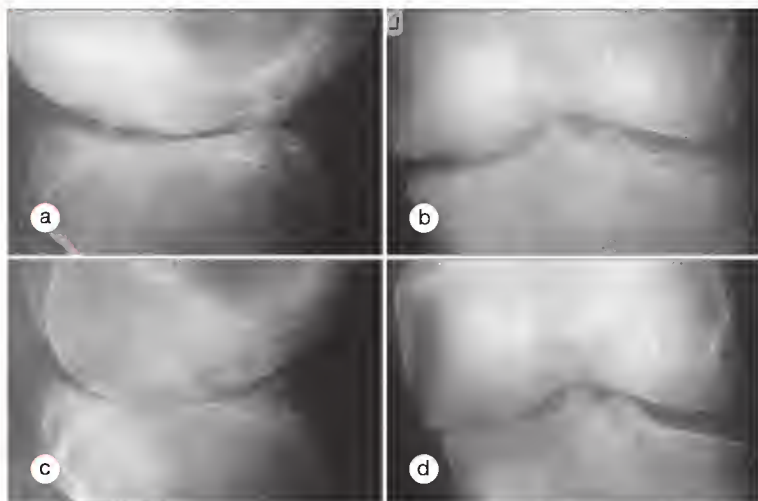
Differences in joint position at radiography affect joint space assessment. With the knee extended (top row), radiography does not reveal joint space narrowing, but in the semiflexed position (bottom row) joint space narrowing is detected. With advanced disease, lateral radiographs in the standing extended knee view (a) show the femoral condyle resting on the anterior rim of the tibia, producing a gap visible as a joint space in the anteroposterior view (b). Conversely, in the semiflexed view of the same knee, the femoral condyle occupies the central region of the tibial plateau (c) with no cartilage present. No joint space is visible in the anteroposterior view (d).
